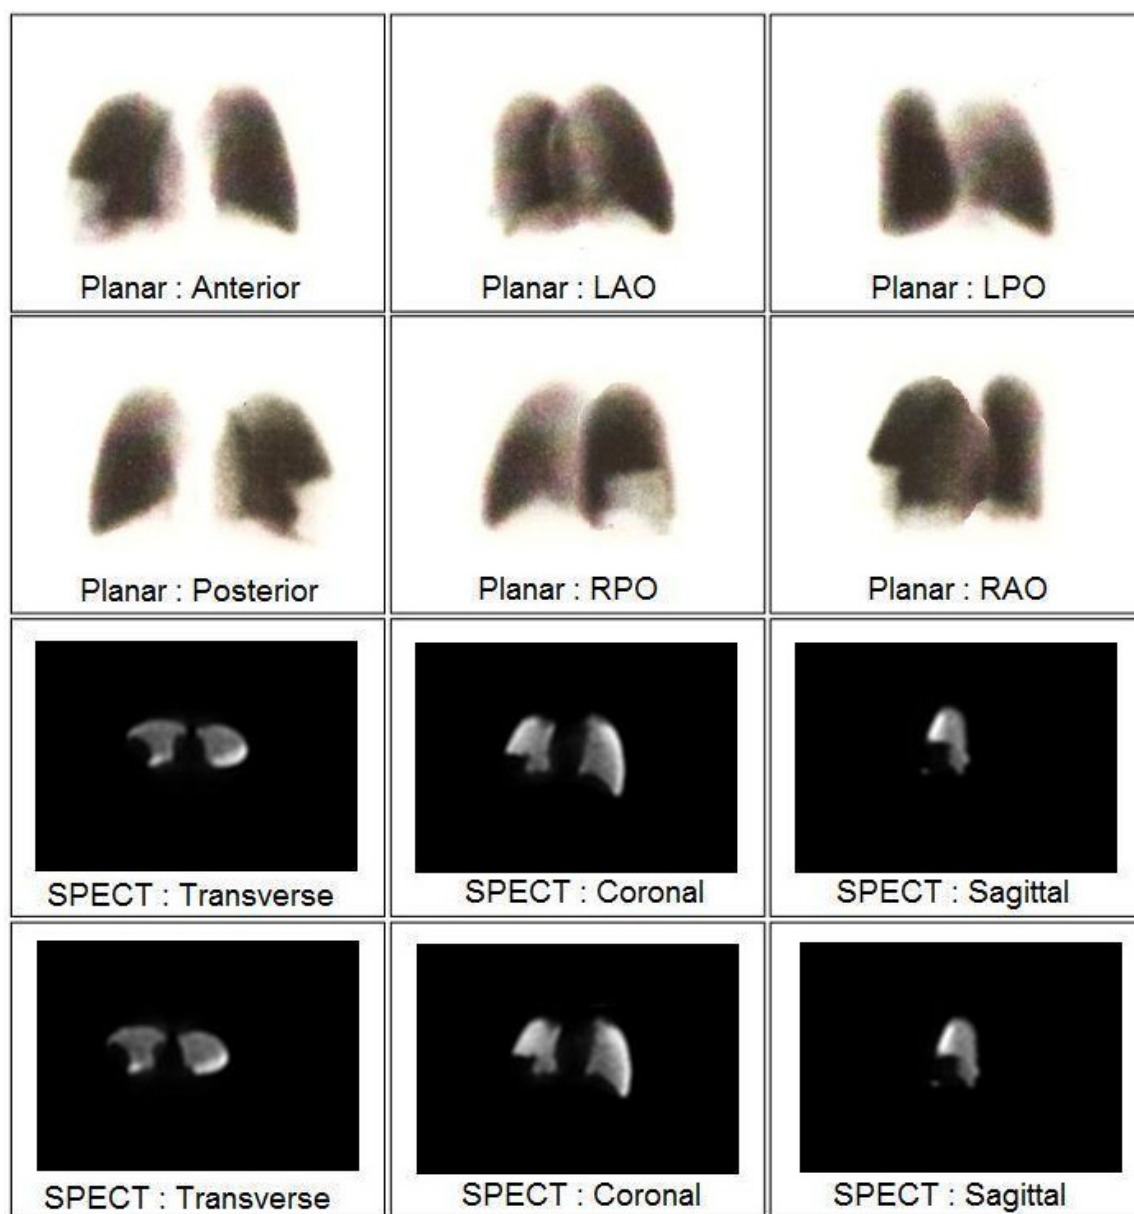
Planar and SPECT images of a perfusion defect within the posterior basal segment of the right lower lobe.
